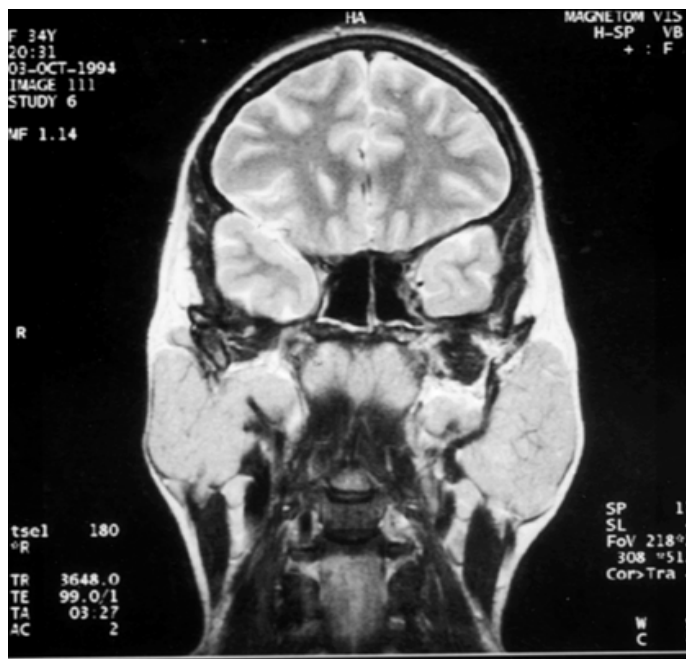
Magnetic resonance imaging scan showing enlarged parotid glands in a female with HIV salivary gland disease. Radioisotopic scans revealed negligible glandular function.
